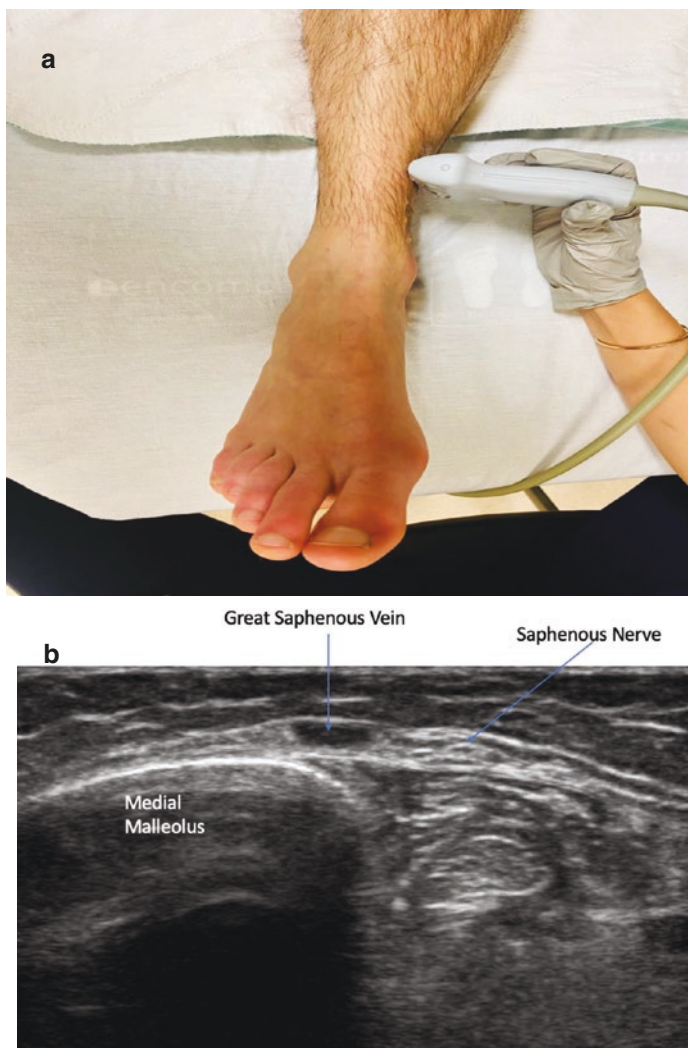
(a) Ultrasound probe placement (upper image) and (b) ultrasound view (lower image) of the saphenous nerve block at the ankle
